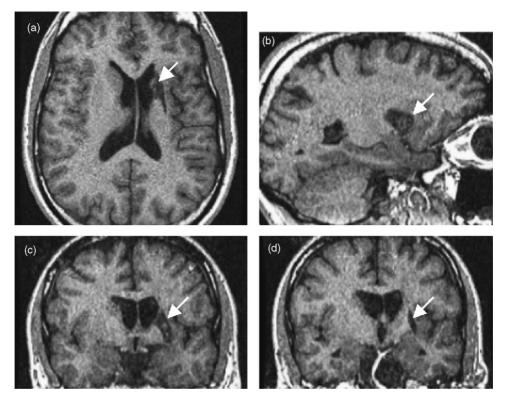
Lesion (arrows) shown in (a) axial, (b) sagittal and (c and d) coronal T1-weighted MR images involving the putamen, external segment of the globus pallidus, anterior internal capsule and head of the caudate on the left hemisphere.
